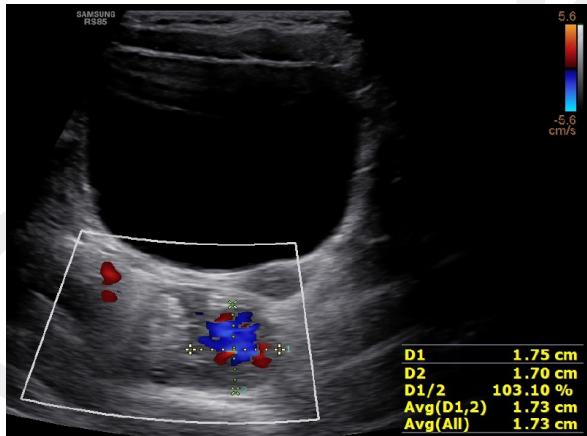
Patient No. 3. Abdominal ultrasonography revealed a well-vascularised, oval-shaped, pedunculated mass measuring 17 × 15 mm in the distal sigmoid colon
